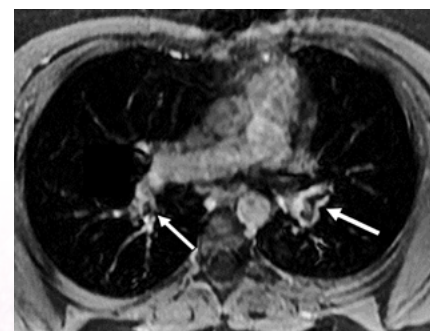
MRI bright blood sequence showing filling defects (arrows) in the main branches of the pulmonary arteries in a patient on oral contraceptives.
